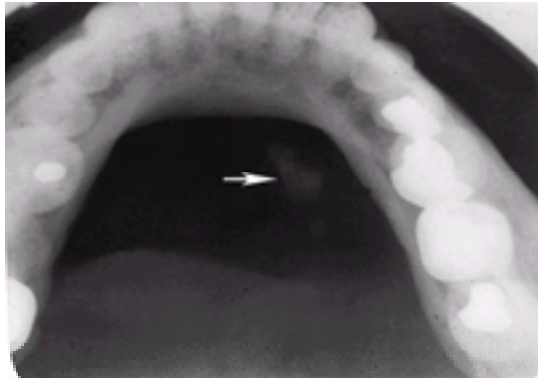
A plain radiograph demonstrating a salivary calculus (arrow) in Wharton's duct.
